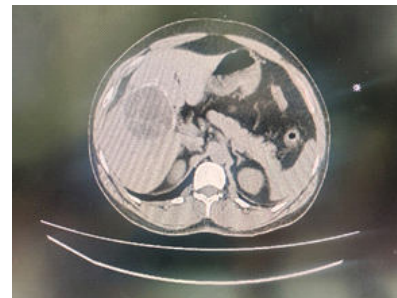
2B & 2C: showing pre-operative CT images of multiloculated hydatid cyst with daughter cysts in axial, coronal and sagittal view respectively.
